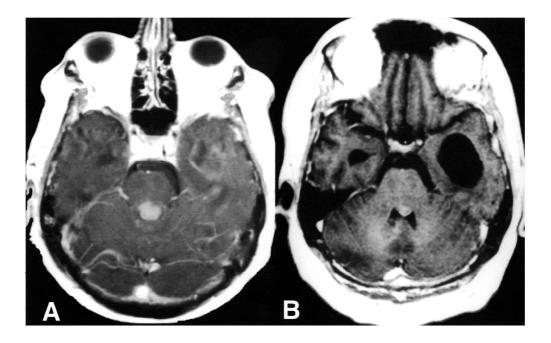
Gadolinium-enhanced T1-weighted spin-echo MRI in the axial plane (A) demonstrating pathological enhancement of the leptomeninges with solid metastasis to the fourth ventricle. Complete regression of the tumor 3 weeks after delivery of focused radiation to the fourth ventricle (B).
